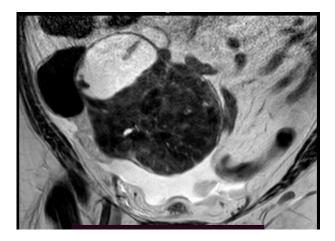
MRI T2 coronal image showing hypointense lesion with cystic component having septa within.
